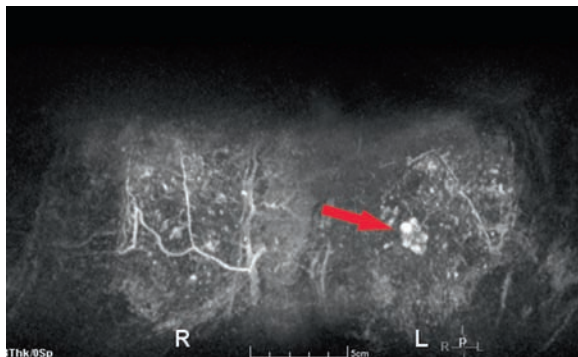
A 35-year-old woman referred for high risk (BRCA2) screening MRI. The contrast-enhanced MRI coronal (looking at the patient from the front, anterior to posterior) image shows contrast uptake in a lobular mass with dark internal septations (*arrow*) typical for fibroadenoma. A biopsy as requested by the patient and confirmed a fibroadenoma
